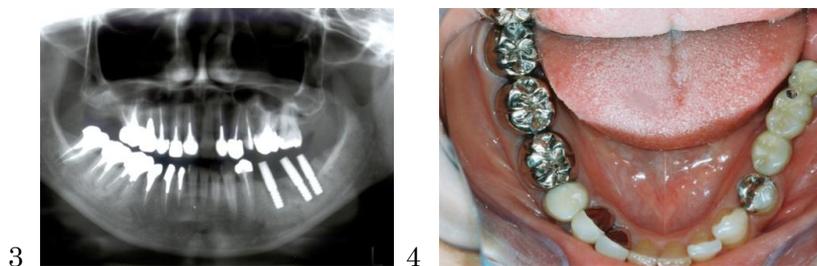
Panoramic radiograph after the implant body installation
